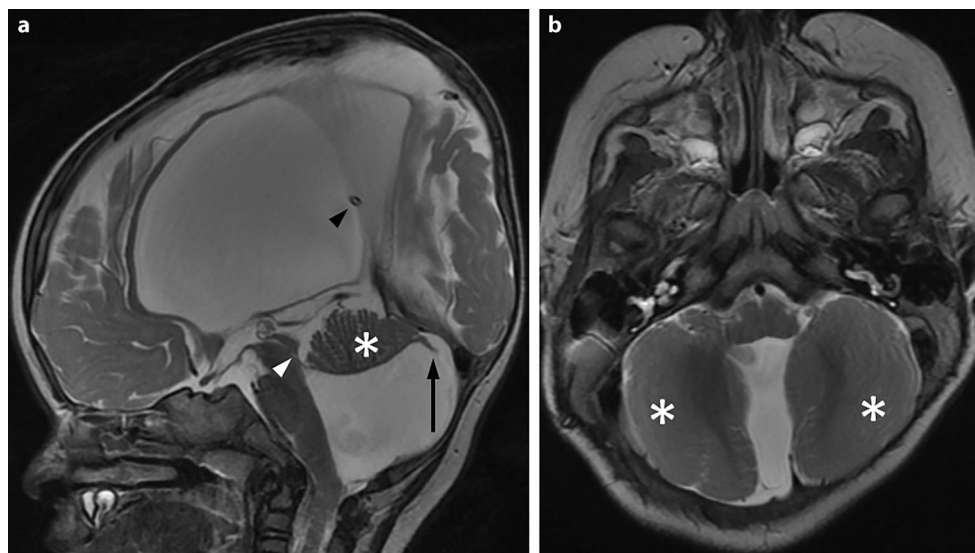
Mid-sagittal (a) and axial (b) T2-weighted fast spin-echo (FSE) images of the brain in a 9-month-old patient after shunt (a, black arrowhead) placement for chronic hydrocephalus in the context of Dandy-Walker malformation. a Occlusion of the Sylvian aqueduct (white arrowhead) with absent flow void has developed postnatally. Configuration of the folia and lobules of the anterior lobe and the upper portion of the posterior lobe of the vermis (asterisk) is approximately normal. The lower portion of the posterior lobe is almost completely missing and in continuity with a “tail” (arrow) that possibly represents ependyma and connective tissue of the extremely enlarged fourth ventricular roof. b The cerebellar hemispheres (asterisks) appear normal in size and structure
